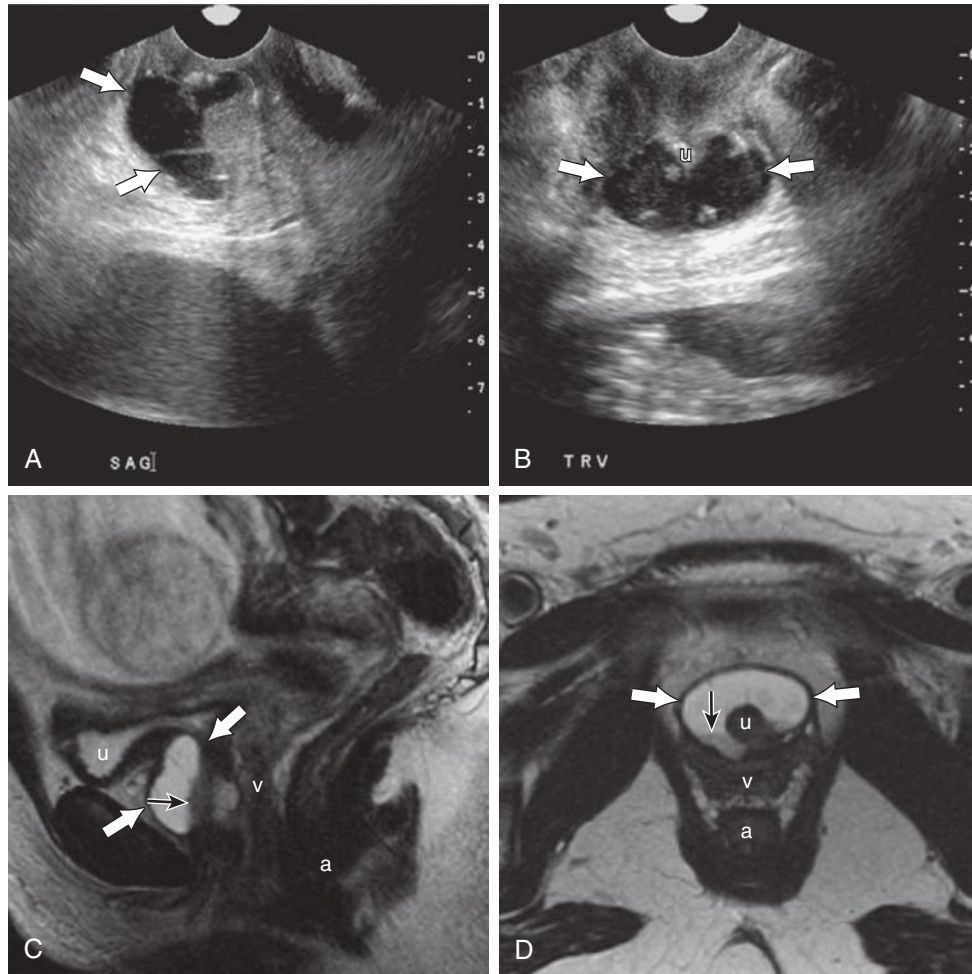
Urethral diverticulum on ultrasound imaging and magnetic resonance imaging. Sagittal (A) and axial (B) gray-scale ultrasound images demonstrate anechoic collection (white arrows) surrounding the urethra. Sagittal (C) and axial (D) T2-weighted images of the pelvis show a high signal intensity horseshoe-shaped cystic lesion (white arrows) surrounding the urethra (u). Note layering dependent debris (black arrow). The location and shape are typical of a urethral diverticulum. a, anal sphincter; v, vagina.
